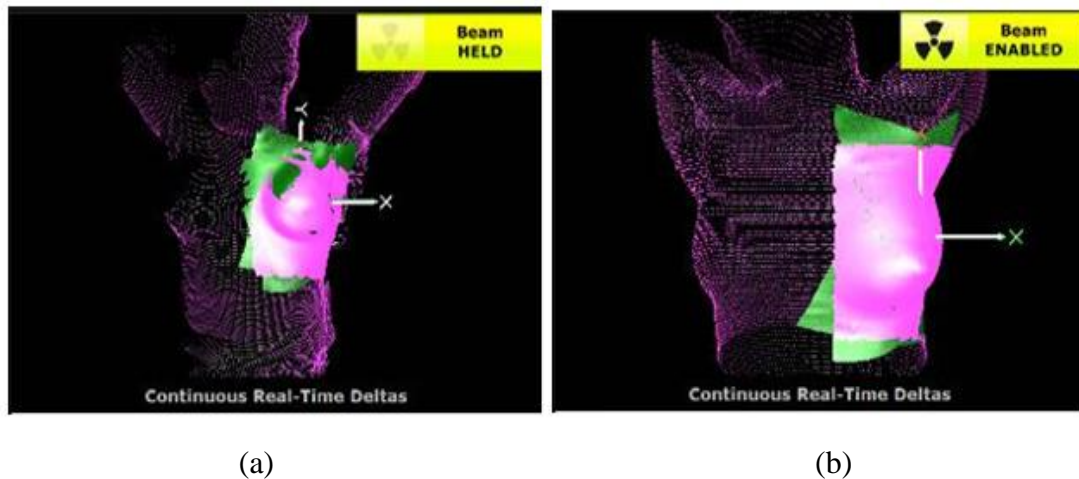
The reference image that (a) generated in the first treatment session by extraction of the surface image from CT data (ART_S) and used (b) the planning CT surface contours (CT_S)
